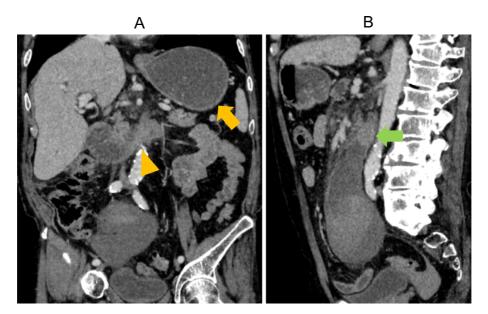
Contrast-enhanced computed tomography images on day 15. The yellow arrow shows a partially visualized stomach expanding with fluid. The dilated second part of duodenum is also visualized, and a radical caliber change at the third part can be seen (yellow arrowhead). The hematoma was bigger than it was on the admission day and unchanged from day 2. It compressed the horizontal part of the duodenum (green allow).
